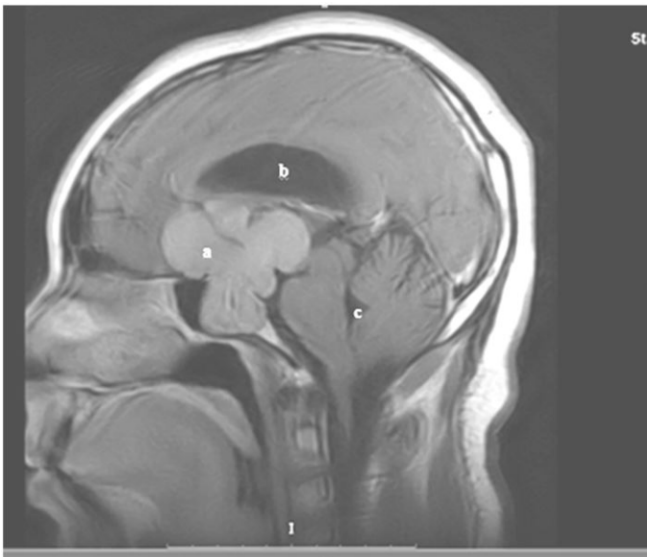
Sagittal T1W+C MR image of the brain showing a lobulated homogeneously enhancing pituitary mass (a) and dilated lateral ventricle (b), with normal 4th ventricle (c)
